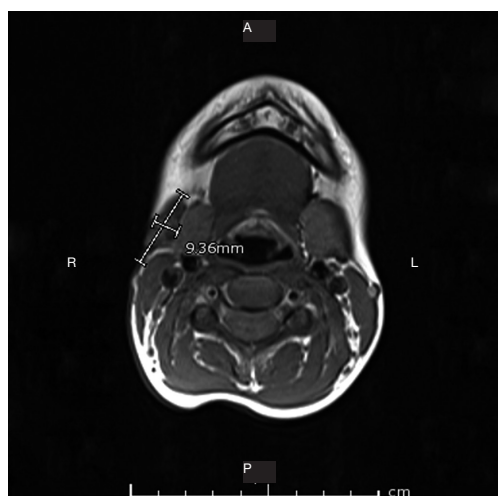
T1 axial MRI image showing nodal mass on the lateral aspect of the submandibular gland prior to surgical excision. L, left; R, right; A, anterior; P, posterior; MRI, magnetic resonance imaging.
